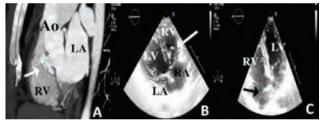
Perimembranous ventricular septal aneurysm. (A) A still frame of a partial sagittal image of cardiac computed tomography shows cauliflower shaped membranous ventricular septal aneurysm with moderate contrast. It has originated just beneath the right coronary sinus of valsalva and protruding into the right ventricle. The ascending aorta and ventricular septal aneurysm are opacified with iodinated contrast medium (white arrow). (B) Partial two chamber parasternal view of transthoracic echocardiography shows a fibrotic, non-contractile right ventricle lobulated, space-occupying structure under aortic annulus (white arrow). (C) Apical four chamber echocardiographic view depicting a prominent eustachian valve (black arrow). Ascending aorta, LA=Left atrium; LV=Left ventricle; RA= Right atrium; RV= Right ventricle.
